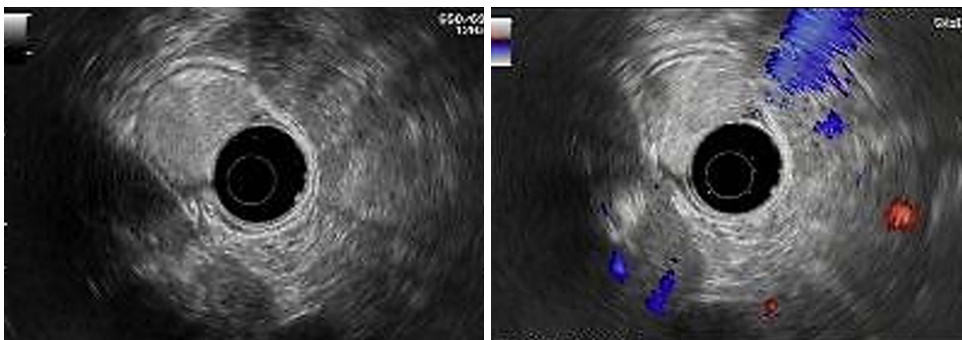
Endoscopic ultrasound examination located the tumor mainly in the submucosa of the gastric wall.
